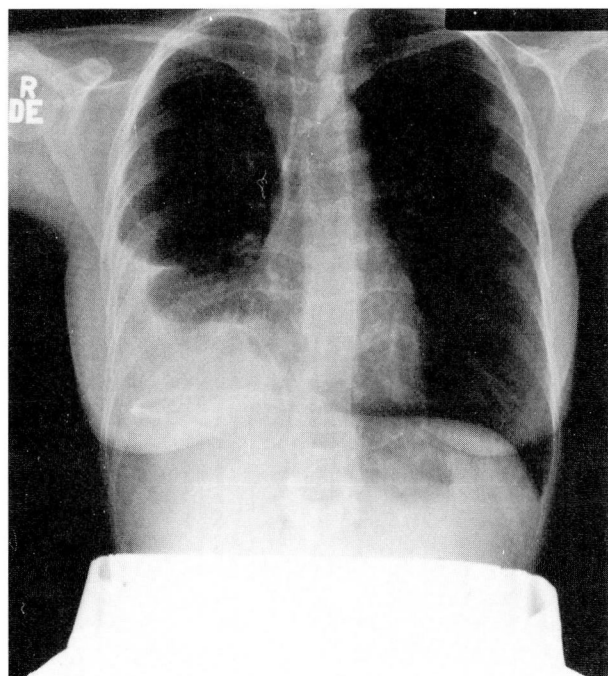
Posterior-anterior and lateral roentgenogram of the chest demonstrating a right pleural effusion and the catheter in the right pleural space.
